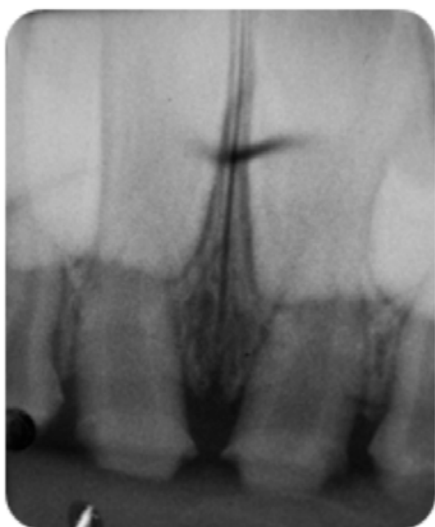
Radiographic examination evidencing carious lesions at the inner half of the dentine of teeth #51, #52, #61 and #62
